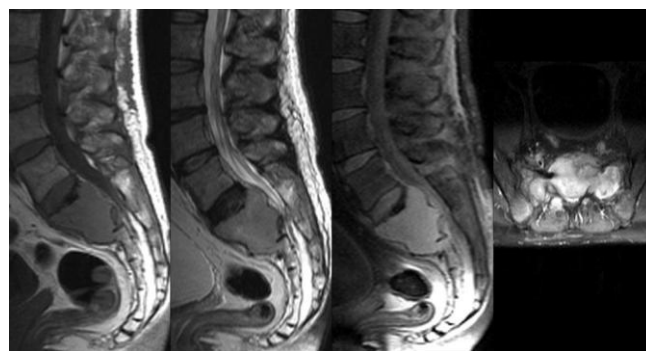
MSCT, MRI of a tumor lesion of the sacral vertebrae
